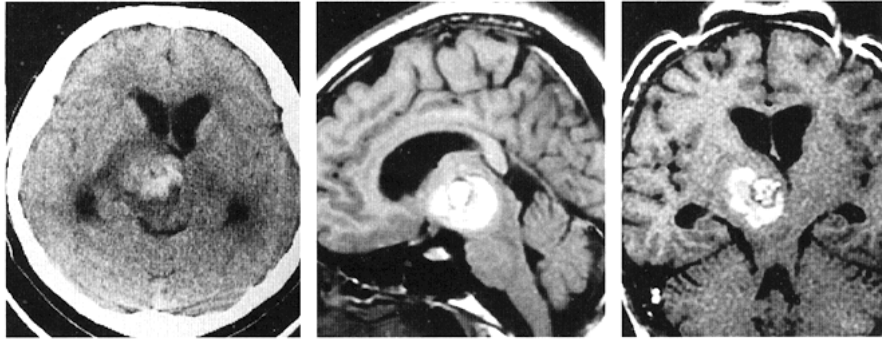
Preoperative CT scan and magnetic resonance (MR) T1-weighted images. *Left*, CT scan demonstrating a mixed-density lesion at the right subthalamic region and dilatation of the lateral ventricles. *Middle*, MR sagittal image showing a heterogeneous signal intensity lesion located at the subthalamic region extending to the cerebral peduncle. *Right*, MR oblique image, 45 degrees from the AC-PC line, obtained for surgical planning, demonstrating that the lesion is accessible from the frontal cortex through the anterior limb of the internal capsule.
